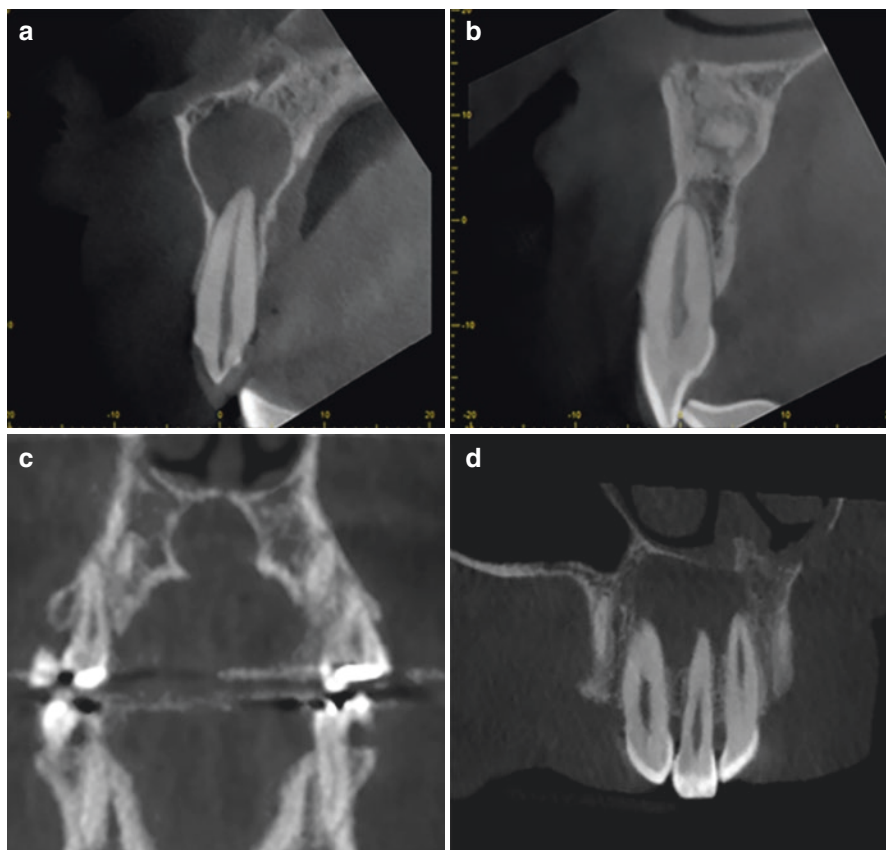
CBCT images of pathologies involving the aesthetic zone. (a) Radicular cyst associated with the apex of tooth #7. (b) Mixed density periapical cemento-osseous dysplasia superior to the apex of tooth #9. (c) Nasopalatine canal duct cyst causing marked expansion of the nasopalatine canal. (d) Keratocystic odontogenic tumor scalloping around the apices of teeth #6–8
